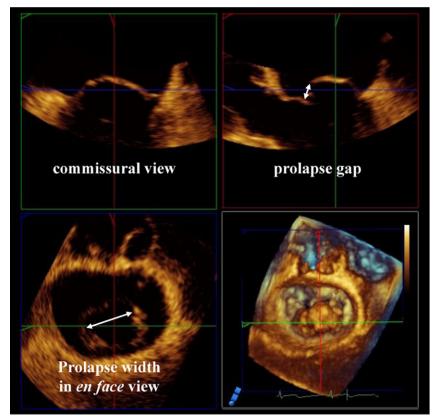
An example of a 3D transesophageal echocardiographic image for the assessment of MV prolapse. The 3D data set was manually cropped using the plane perpendicular to the MV until the largest cross-sectional prolapse gap and width of the MV were observed.
